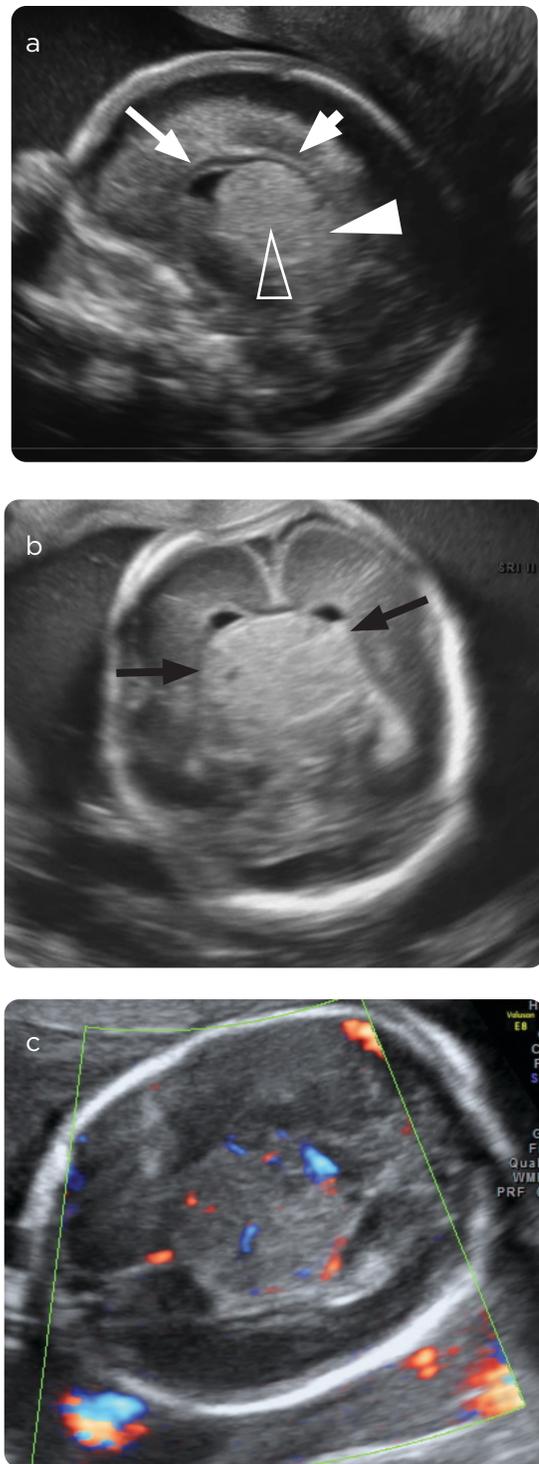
Immature teratoma of the pineal gland. Gestational age 20 weeks and 5 days. a) Neurosonography with mid-sagittal plane. Mass that originates in pineal region (solid white arrowhead) and extends in anterior direction to the third ventricle and thalamic region (empty white arrowhead), splenius and corpus callosum trunk (solid short white arrow) and reaches the posterior margin of cavum septum pellucidum (solid long white arrow). In caudal direction it reaches the quadrigeminal plate (empty long white arrowhead). b) Neurosonography with coronal plane. The lesion crosses the midline and affects both cerebral hemispheres with an impression on the medial wall of the lateral ventricles (black arrows). c) Eco-Doppler Neurosonography in axial plane. The mass presents moderate vascularization.
